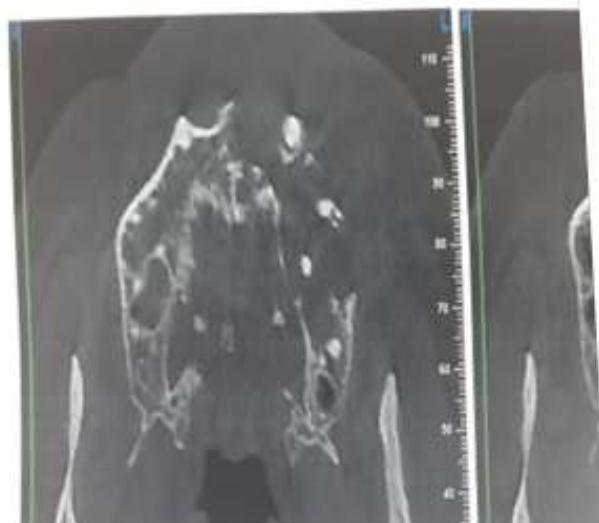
Axial cone beam CT scan view show huge defect of left maxilla.
